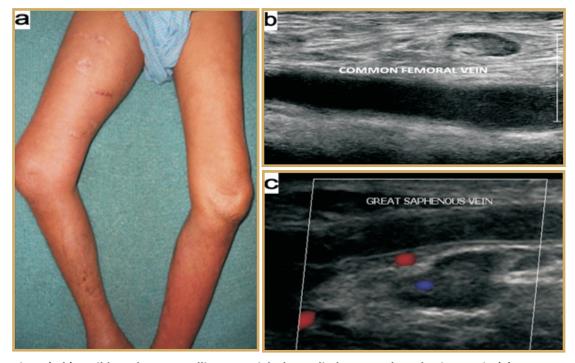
(a-b) : Mild erythema, swelling over right lower limb. Acute thrombosis seen in (a) common femoral vein on doppler study extending into sapheno-femoral junction and proximal great saphenous vein (b, c).
